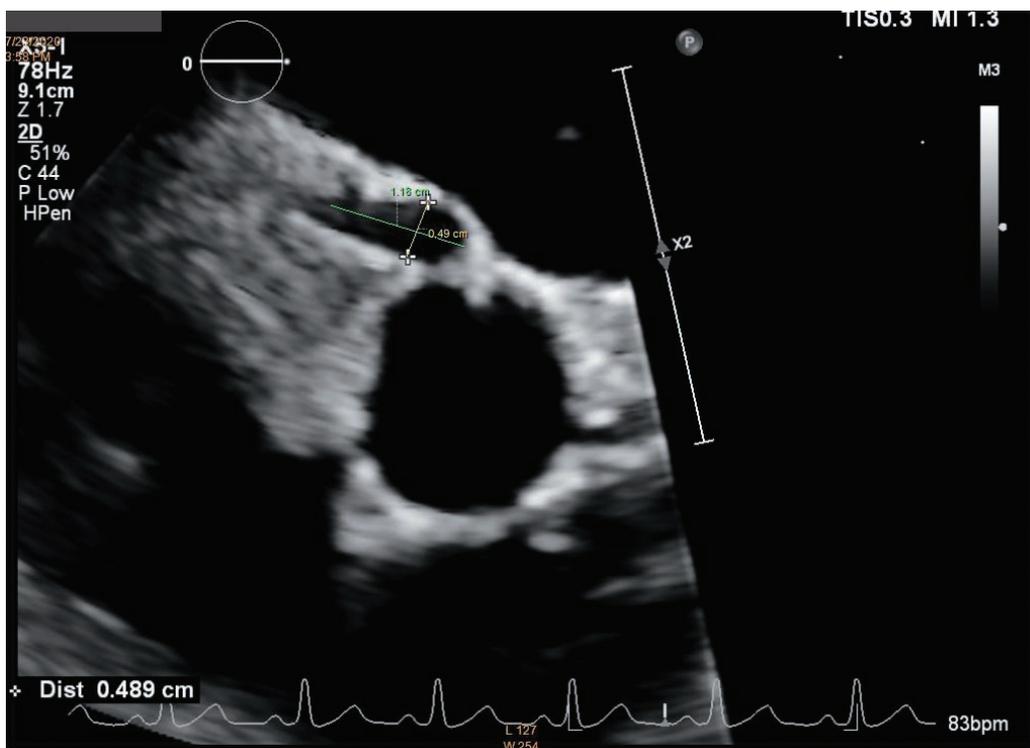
Echocardiogram showed right coronary aneurysm.
